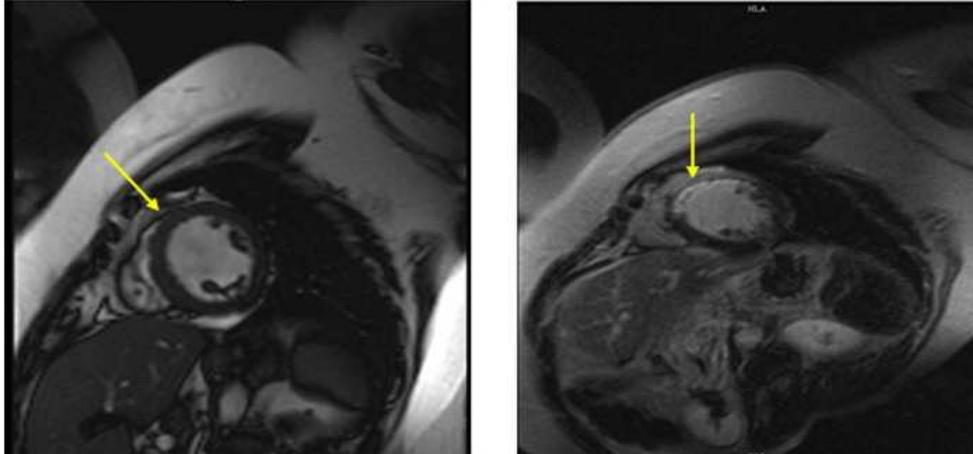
Coronal oblique MRI: early (a) and late Gad enhancement (b) images show scarring of the apex and distal parts of both anterior wall and anterior septum as hyper intense areas in the late images compared to the early one (arrows).
